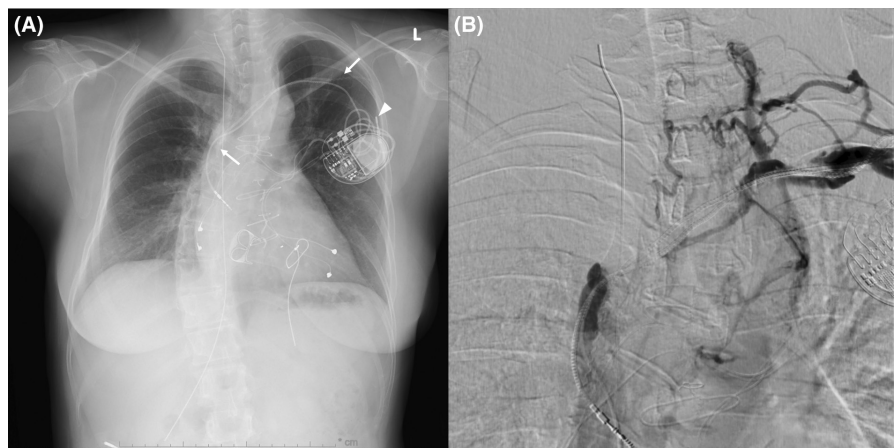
(A) Chest X-ray showing that the transvenous (TV) atrial and epicardial ventricular leads are attached to the generator but the epicardial atrial lead is not (arrowhead). A TV right ventricular lead implanted via the left subclavian vein was cut at the proximal and distal ends of the lead (white arrows). (B) Venography from the left subclavian vein and superior vena cava (SVC) demonstrates total occlusion between the innominate vein and SVC with extensive venous collaterals.
